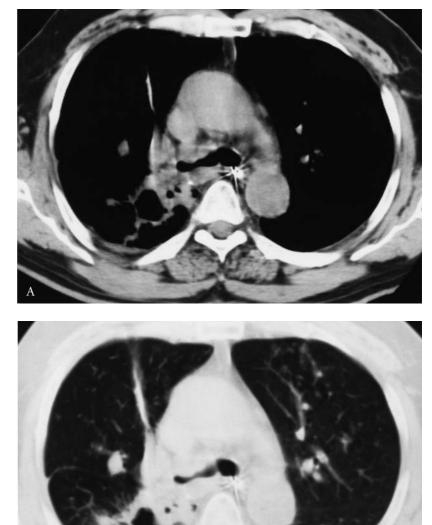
Tuberculous bronchial stenosis, hyperplastic stage. Computed tomography scan demonstrates thickening and nodularity of the right main and right upper lobe bronchi associated with right hilar adenopathy (A) and cavitation of the right lower lobe (B).
